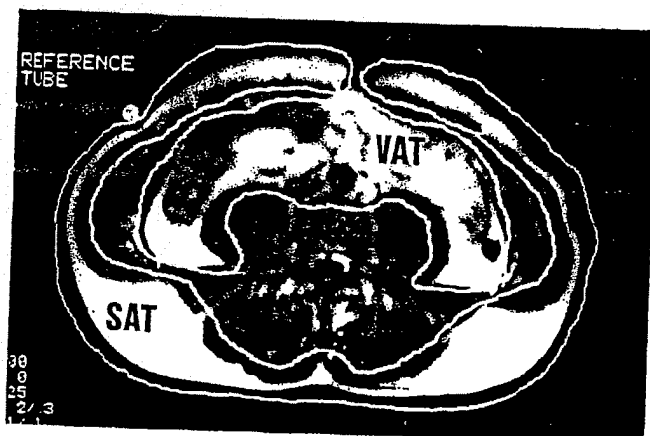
Magnetic resonance imaging: Axial T1-weighted image obtained at the level of umbilicus. Two large regions of interest (ROI A and ROI B) are drawn manually. The ROI A includes the largest cross-sectional area of subcutaneous adipose tissue (AT) and the ROI B includes the largest cross-sectional area of visceral adipose tissue. The next step consists in highlighting and counting the pixels which correspond to AT in each ROI. The reference tube allows to determine the threshold of AT.
